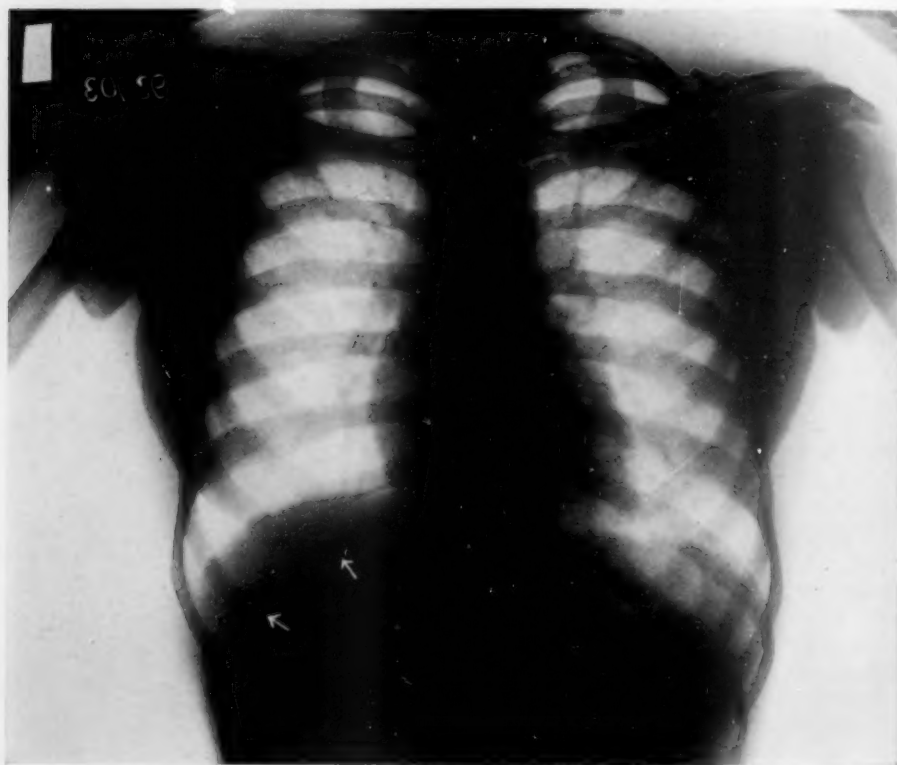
X-ray of Case II. The arrows point to the area of destruction in the rib.
